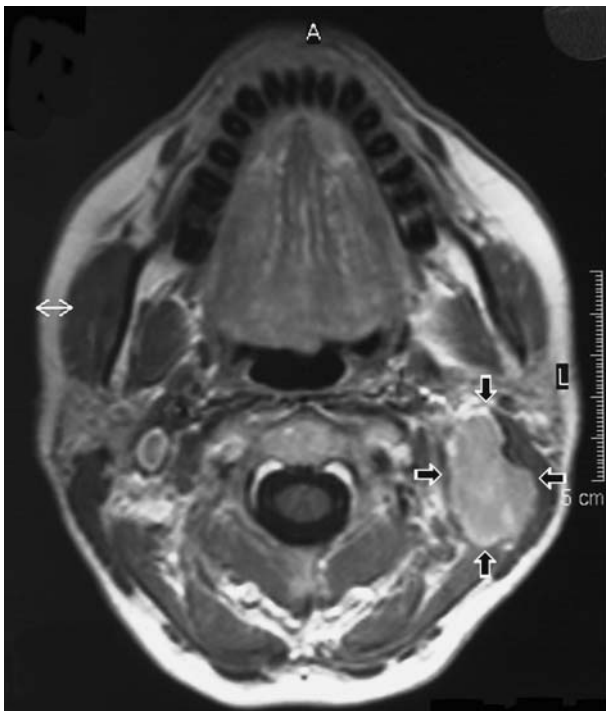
T1-weighted axial cervical MRI with gadolinium showing cervical mass at C2-level.
